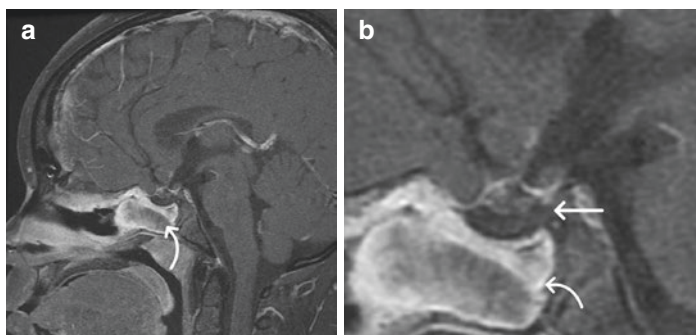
Posttreatment craniopharyngioma (CP) MRI images of a 13-year-old boy with recurrent craniopharyngioma with pan hypopituitarism and central DI. (a, b) Postcontrast sagittal T1 with fat saturation showing post-surgical distortion in the sella following endoscopic endonasal resection and radiation therapy. The pituitary gland, posterior pituitary bright spot, and the pituitary stalk are not well visualized (straight white arrow). There is enhancement of the mucosal flap in the sphenoid sinus (curved arrow)
